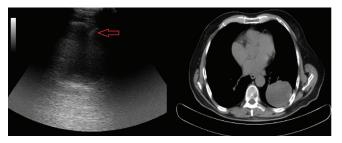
Thoracic USG-guided TTFNAB procedure in a patient with peripherally located tumor in the left lung in a thoracic CT. (Sonographically a 6x6 cm hypoechoic lesion, the biopsy needle is marked with a red arrow)
